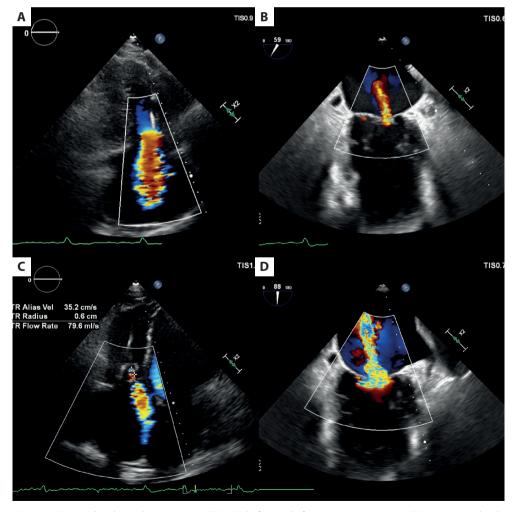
Tricuspid and mitral regurgitation (TR/MR) before and after treatment. A. Severe TR in preprocedural transesophageal echocardiography (TEE). B. Periprocedural TEE image of MR before TR treatment. C. TR reduction in postprocedural TEE. D. Periprocedural TEE image of acute MR worsening after TR reduction
